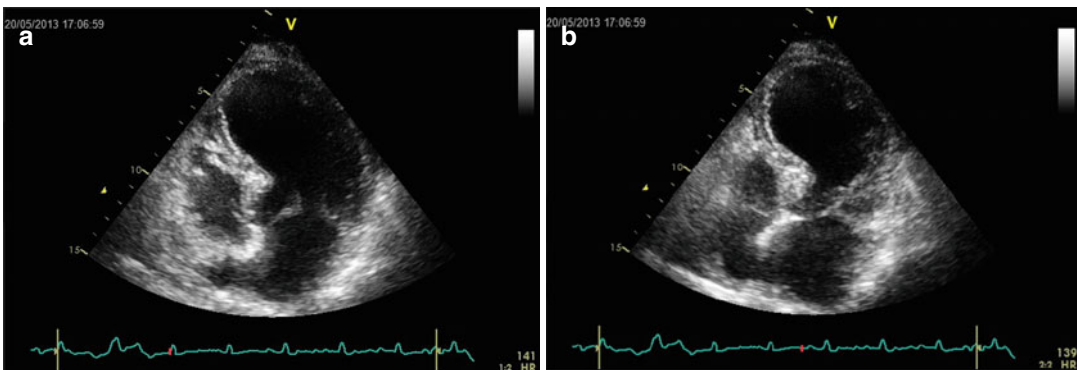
Echocardiographic picture recorded at rest during systole (a) and during diastole (b); typical LV ballooning during systole is visible, characterized by complete
